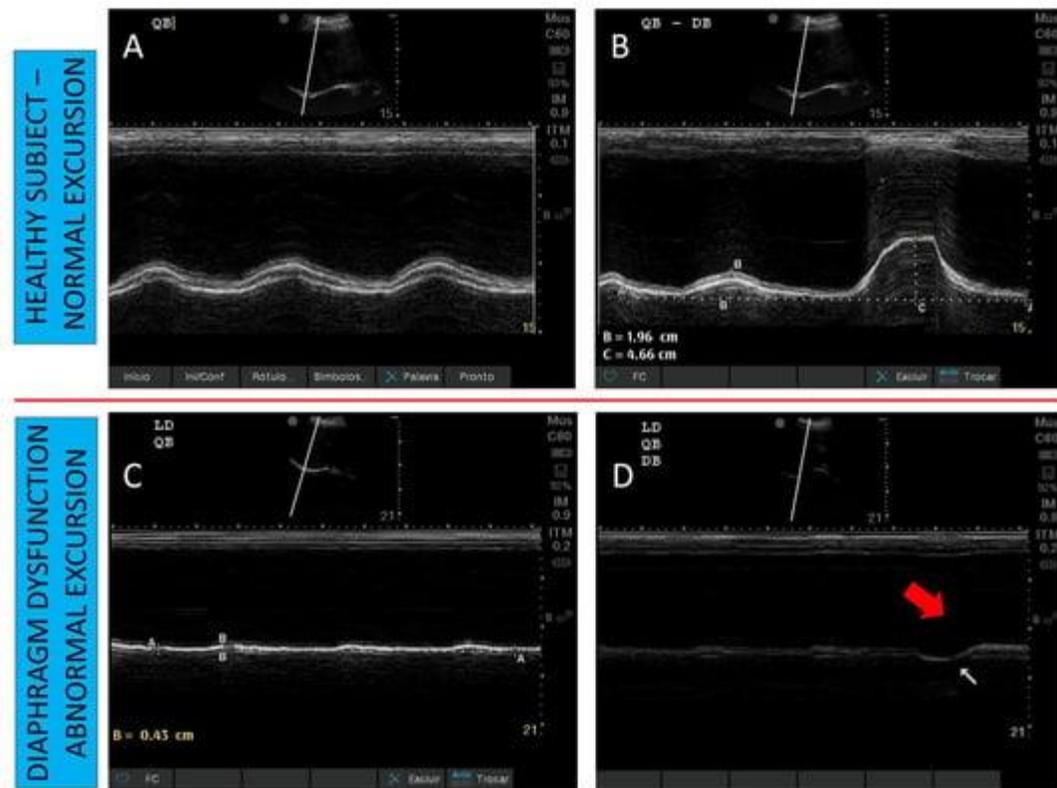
Diaphragm ultrasound to monitor dysfunction according to diaphragmatic excursion. (Panel A): Normal excursion during tidal breathing in a healthy subject. (Panel B): Normal excursion during tidal and deep breathing in a healthy subject. (Panel C): Reduced excursion during tidal breathing in a patient with diaphragm dysfunction. (Panel D): Absent excursion during tidal breathing, and paradoxical excursion during deep breathing (red arrow) in a patient with diaphragm dysfunction.
